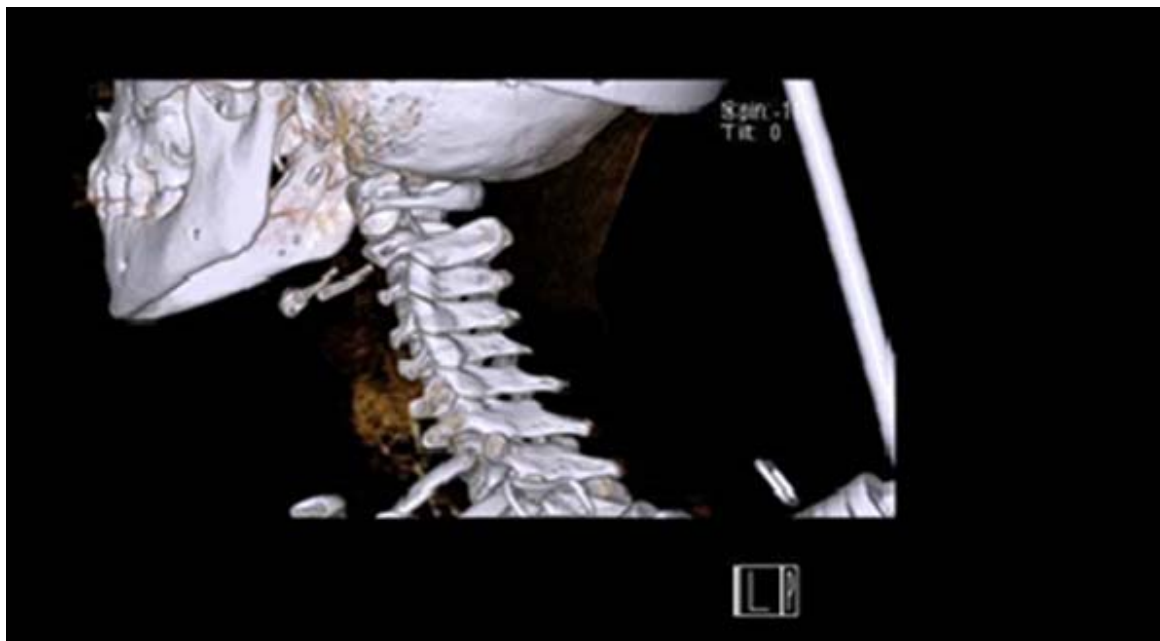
Cervical and brain MRI showing rotary articular subluxation of the C1-C2 tract and signs of inflammation of the adjacent neck tissues.
